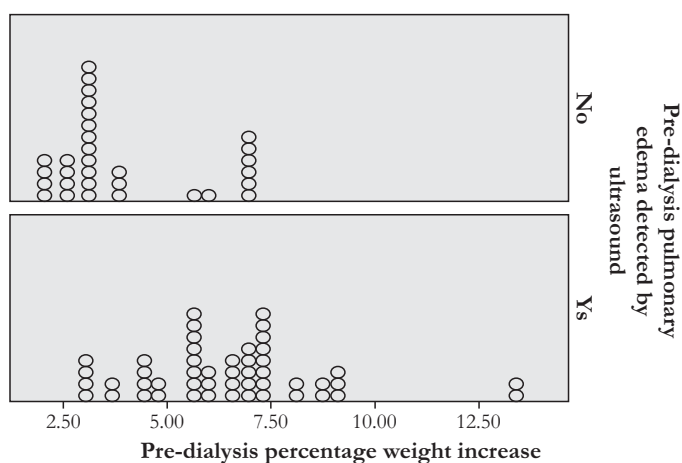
Pre dialysis pulmonary edema determined by lung ultrasound
